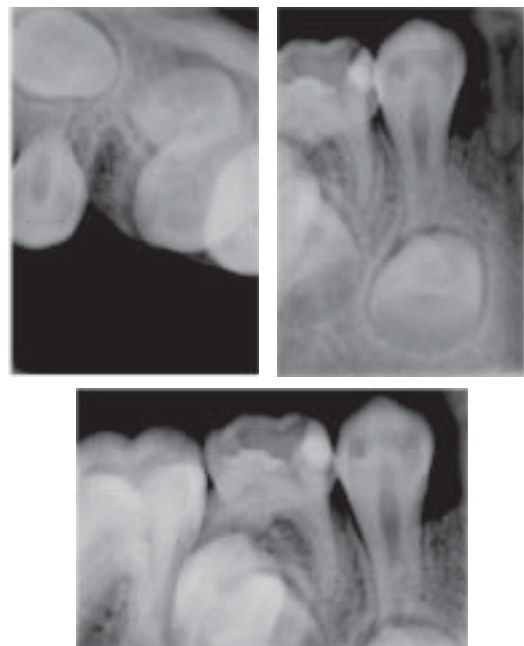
(a,b,c) Intraoral periapical and occlusal digital radiographs showing two supernumeraries in 44 and 45 region
